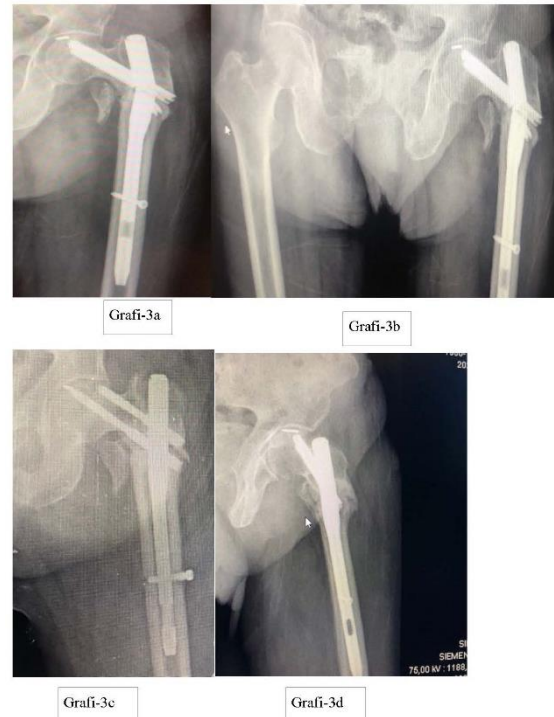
a: Hip AP X-ray, Proximal PFN fracture occurring 12 months after the 1st PFN fracture revision, and the proximal fracture of the screw locking the sliding screw. b: The trochanter minor was seen to be displaced on the pelvic AP X-ray. c: On the 2nd hip AP X-ray, 5 months after the 2nd PFN fracture revision, the fracture healed but the trochanter minor was seen to be displaced. d: Callus development at the fracture line was seen on the hip lateral radiograph, 5 months after the 2nd PFN fracture revision
